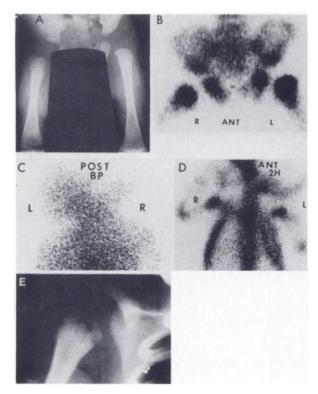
Neonatal osteomyelitis of proximal right femur in 23-day-old in which (A) radiograph shows destruction in medial aspect of proximal right femur, whereas (B) pinhole view of hips is normal. Neonatal osteomyelitis of proximal right humerus in 29-day-old female. (C) blood pool and (D) delayed bone scan images show no hyperemia with no increased radioactive uptake in right humerus despite (E) radiograph of shoulder with humeral destruction and periosteal reaction.
